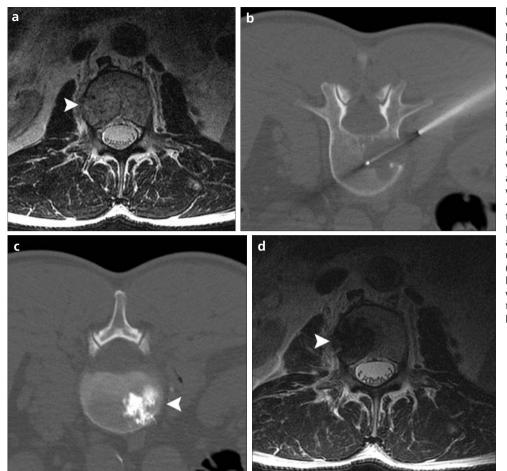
a-d. A 59-year-old man with metastatic RCC was found to have a lytic mass (arrowhead) in the body of the L2 vertebra, which was consistent with a metastasis as shown on T2-weighted MRI (a). The patient was referred for percutaneous RF ablation, followed by vertebroplasty to prevent a potential compression fracture. Following a biopsy, an internally cooled RF ablation electrode (b) with a 2 cm active tip (Covidien) was placed within the mass through a 13 G introducer, and RF energy was applied over 8 min, starting at 40 watts and increasing gradually to 120 watts. After completion of RF ablation, the same introducer and CT fluoroscopy guidance were used and polymethylmethacrylate (arrowhead) was injected into the lytic lesion (c). Follow-up MRI (d), which was obtained the next day, showed that the lytic lesion is filled with T2hypointense cement (arrowhead).
